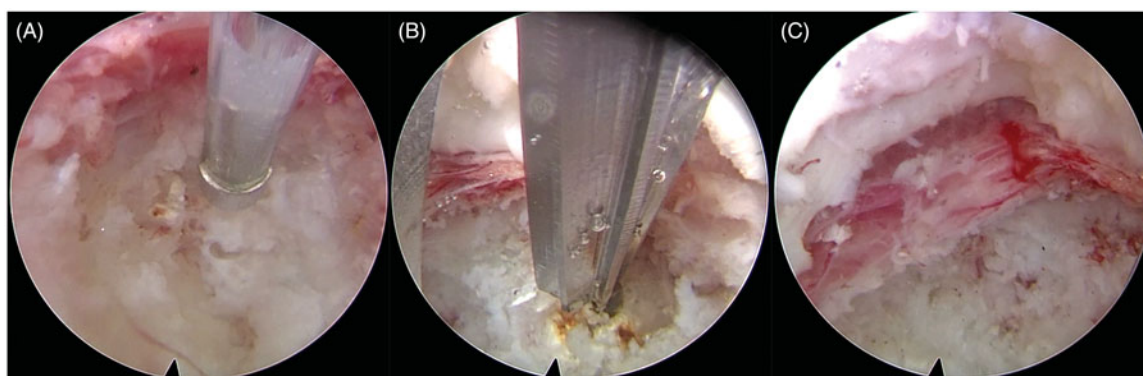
Endoscopic image showing ongoing ultrasonic osteotomy of the calcified intervertebral discs. (A: expose the calcified protrusion; B: remove the calcification with ultrasonic osteotomy; C: calcification is effectively removed).
